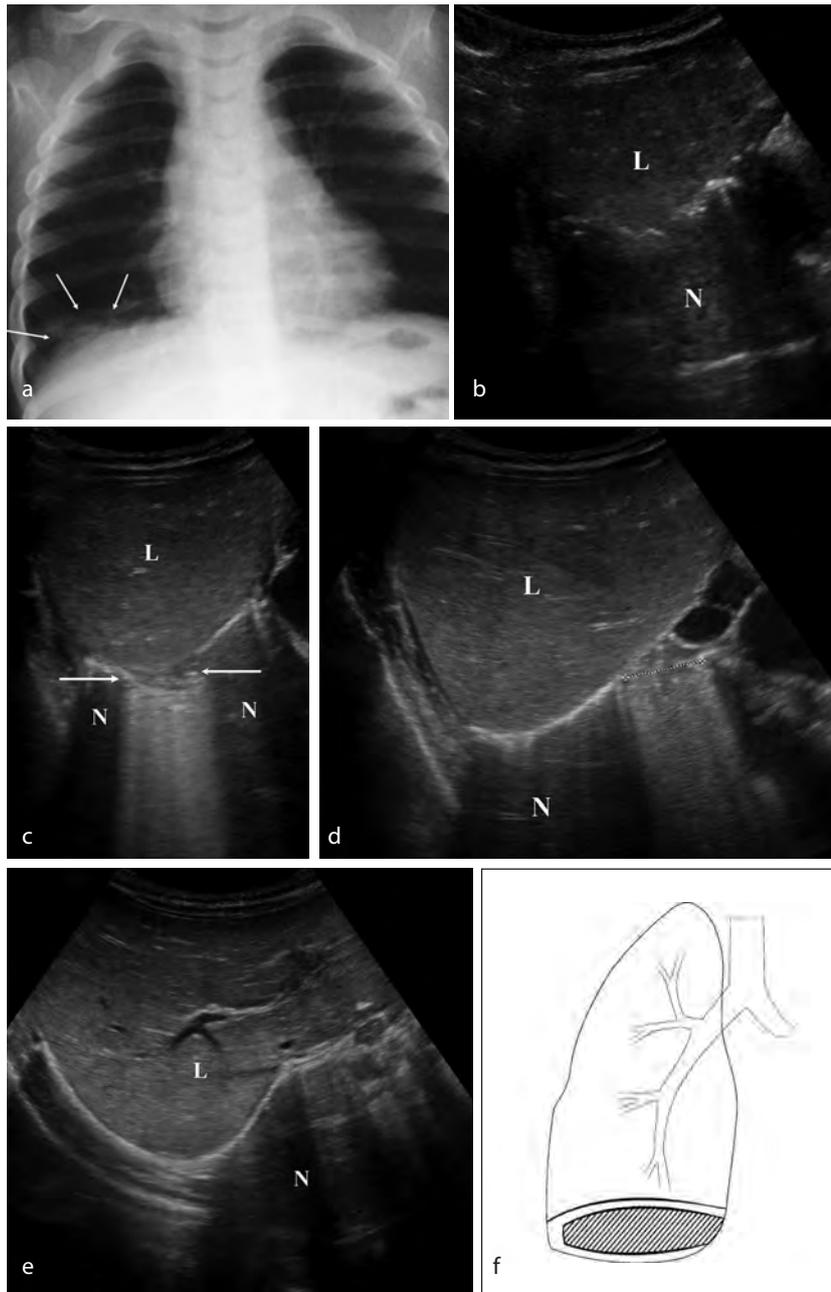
a) Chest X-ray showing a pulmonary consolidation within the right lung base (arrows). This consolidation went unmarked using a trans-thoracic lung ultrasound approach before CXR. However, trans-hepatic examination of the right lung base (b - e), from the most anterior (b) to the most posterior (e) section detected this pulmonary pathology. Images b and e show a normal ultrasound pattern of the “mirror image” phenomenon (N), while in the middle sections of the right lung base there are lung consolidations marked with arrows (c) and asterisks (d), with a discreet air-bronchogram. Note the normal lung ultrasound pattern adjacent to them (N), especially important laterally, because pneumonia does not abut on the lateral pleural surface which is accessible by a low trans-thoracic approach. L - liver. f) Scheme of the right lung with an area within the lung base (marked with oblique lines), which is only accessible to visualization by ultrasound when using the trans-hepatic approach. This area is not in contact with either anterior, or lateral, or posterior pleura, which is mandatory for trans-thoracic visualization, but only with basal pleura.
